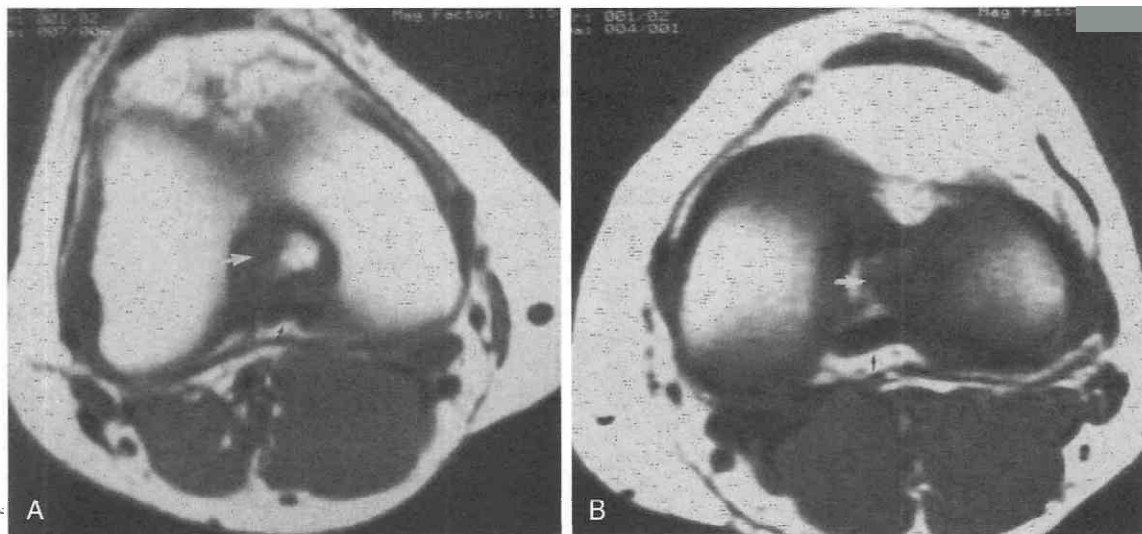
Anterior cruciate ligament (ACL)–posterior cruciate ligament (PCL) on the axial view. Axial T1-weighted images show the normal ACL flattened against the lateral femoral condyle (*white arrows*). The PCL is always better seen as a low-signal-intensity structure coursing posteriorly and laterally (*black arrows*).
